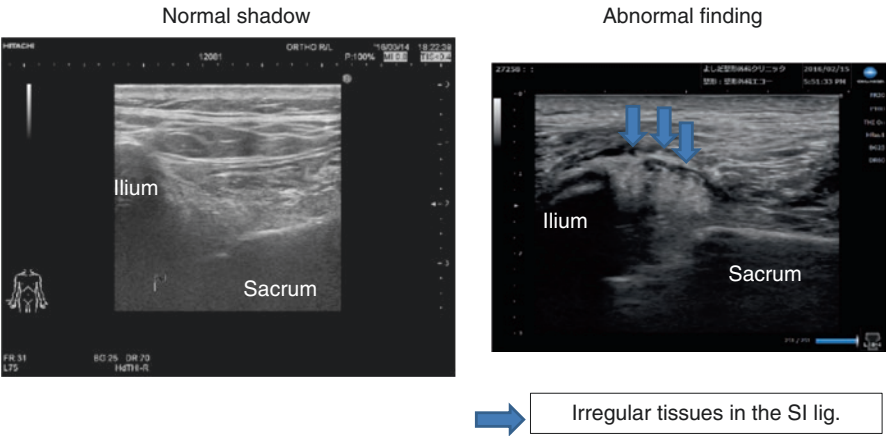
Ultrasound findings. From Shinichi Yoshida
